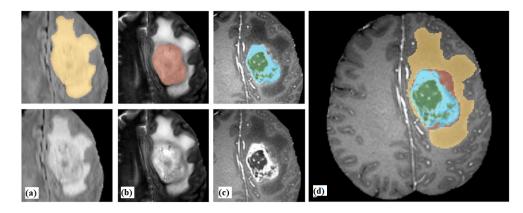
Manual annotation of the tumour structures in different MRI images. (a) The whole tumour appear bright in FLAIR image. (b) The tumour core is visible in T2 image. (c) The enhancing tumour structure visible in T1Gd surrounding the necrotic components of the core. (d) All tumour structures combined to generate the final labels : edema (yellow), non-enhancing tumour (brown), necrotic (green), and enhancing tumour (blue) [5].
